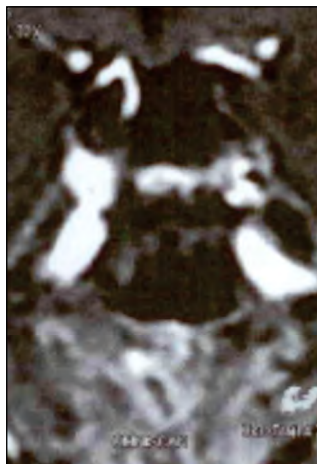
Magnetic resonance imagery of pituitary micro-corticotropinoma on a young adult male
